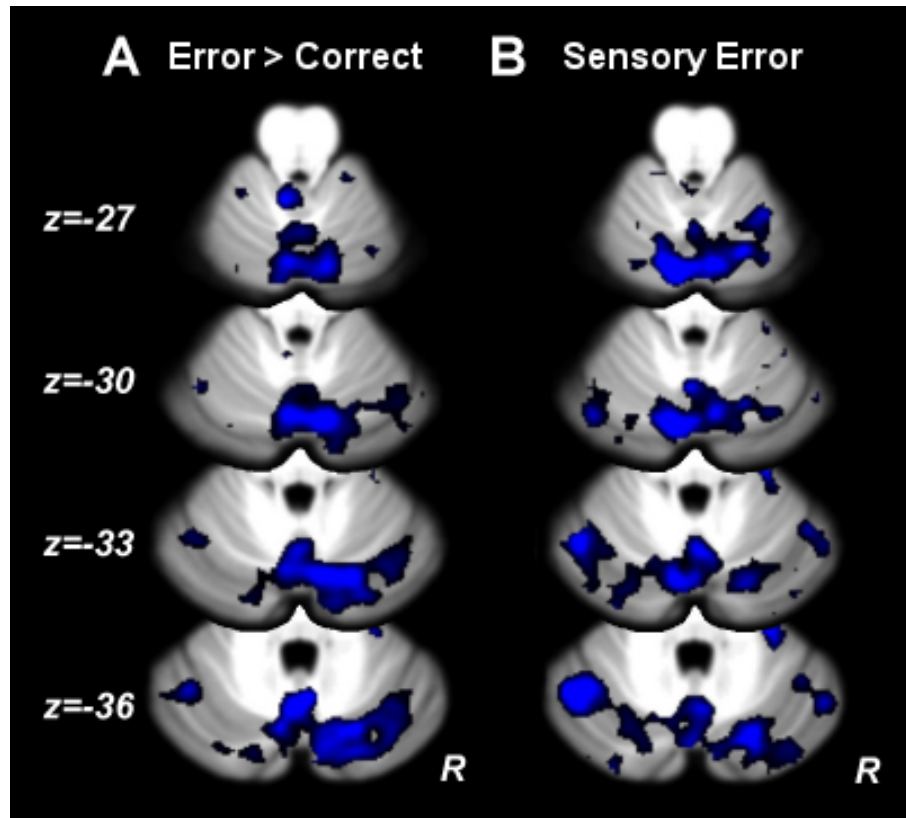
MRI without heartrate correction. A) The effect of errors. In blue are regions more active for correct trials than error trials. No regions are more active during errors. B) Errors conveyed by a sensory signal. In blue are regions more active during trials in which no sensory stimulus was present, or an expected sensory stimulus was present, compared to trials in which the sensory stimulus conveyed an error signal. No regions are more active during trials in which the sensory stimulus conveys the error.
